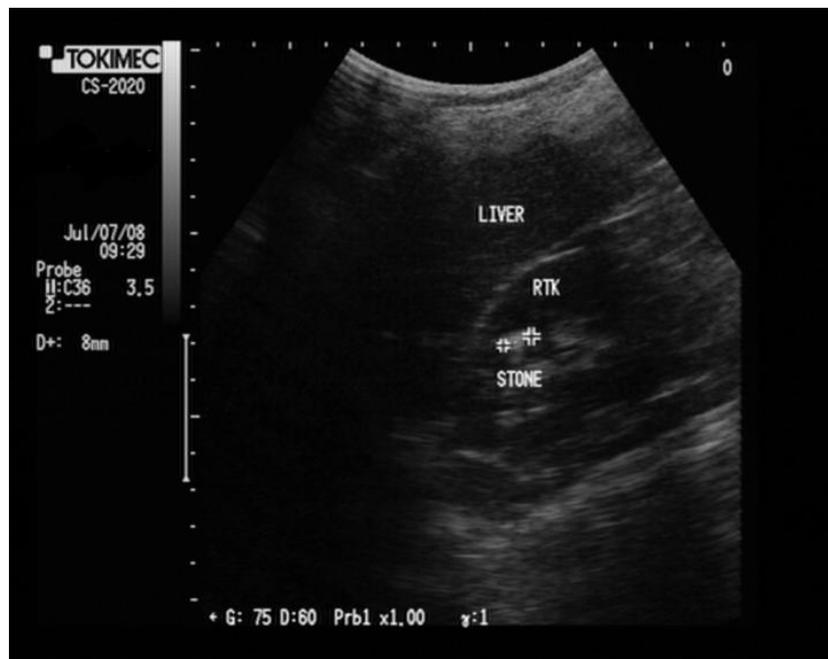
Longitudinal renal sonogram in TB patients; pelvicalyceal calculi
